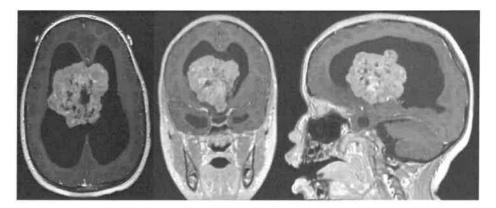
A large acute symptomatic SEGA at presentation in a 7-year-old. Contrast-enhanced MRI.
